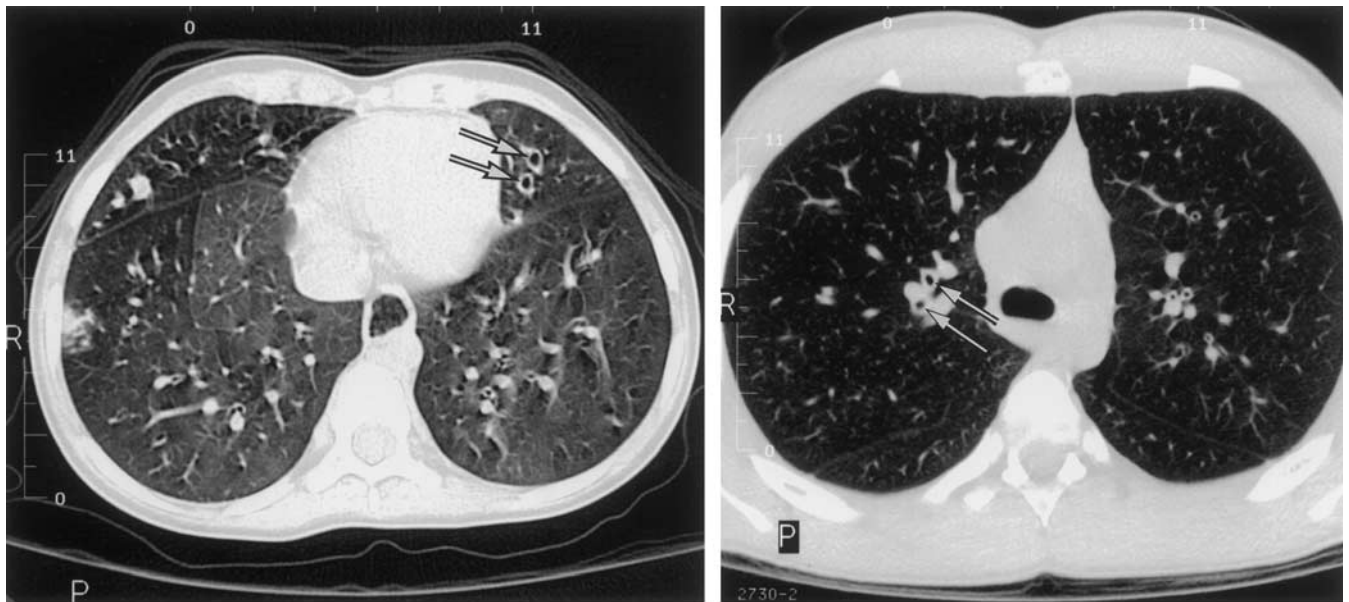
(a) Thin-section CT scan obtained in a child with cystic fibrosis. Two bronchiectatic bronchi are seen in the lingula (arrows). These bronchi were identified as having mildly thickened walls. This CT scan was used as one of the imaging standards. (b) Thin-section CT scan obtained in a child with asthma. Two right upper lobe bronchi (arrows) are seen with approximately the same outer bronchial diameter as those seen in a. After comparison with the standard, these bronchi were classified as having thickened walls.
